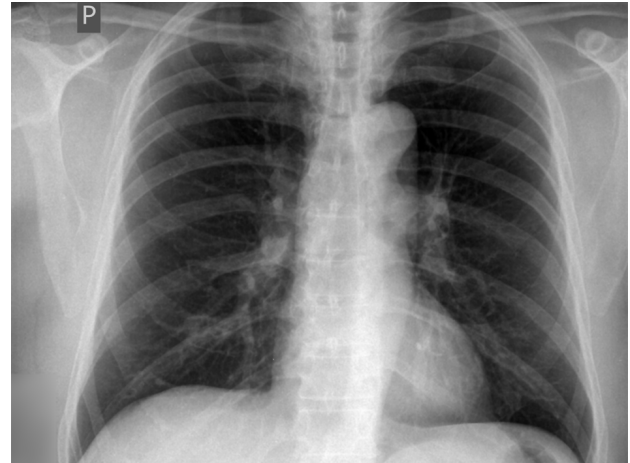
Chest X-ray performed in November 2010
